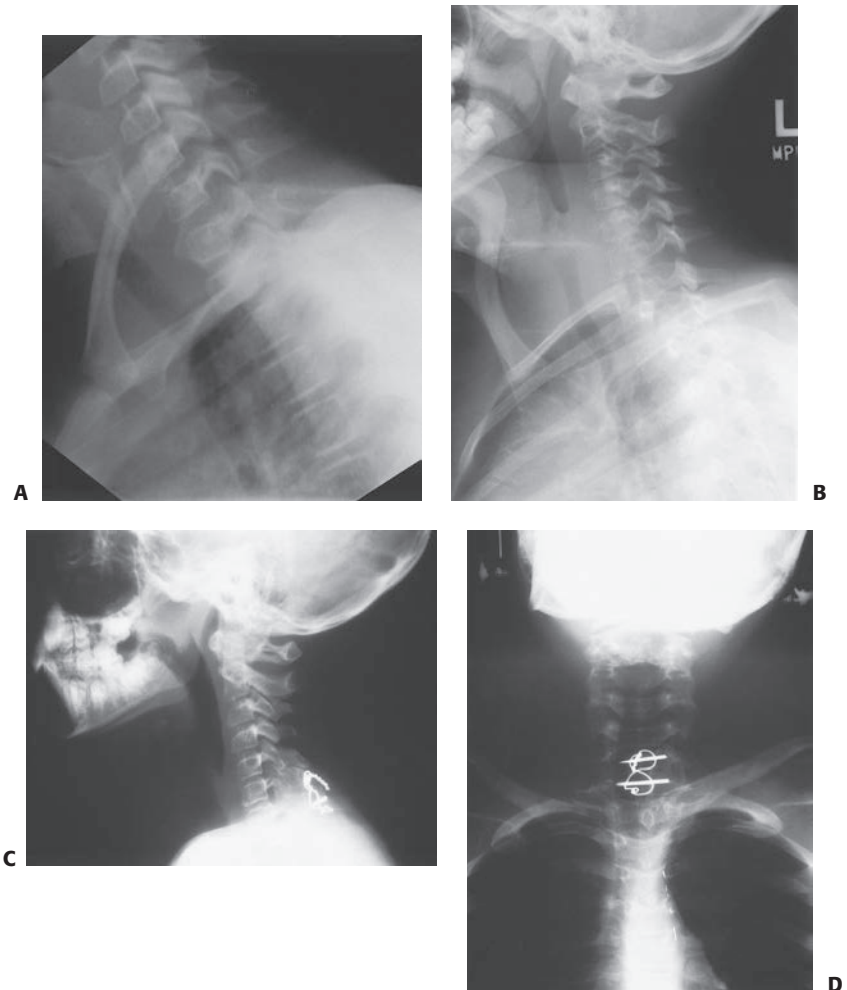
A, B: Lateral radiograph of a patient with the so-called perched facets, demonstrating a facet dislocation. C, D: Lateral and anteroposterior radiographs after reduction and posterior arthrodesis.
